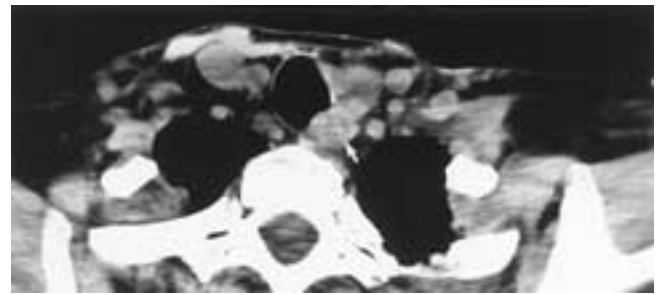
Metastatic squamous cell carcinoma. Axial CT scan shows an enlarged metastatic node in the left tracheoesophageal sulcus (arrow).
